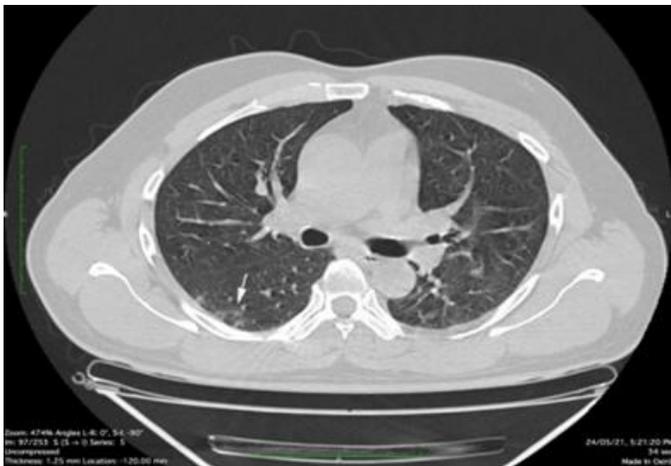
Axial section of HRCT Chest of 49-year-old male after 2 doses of Covishield showing faint ground glass opacities in superior segment of right lower lobe. (CTSI = 2/25).
